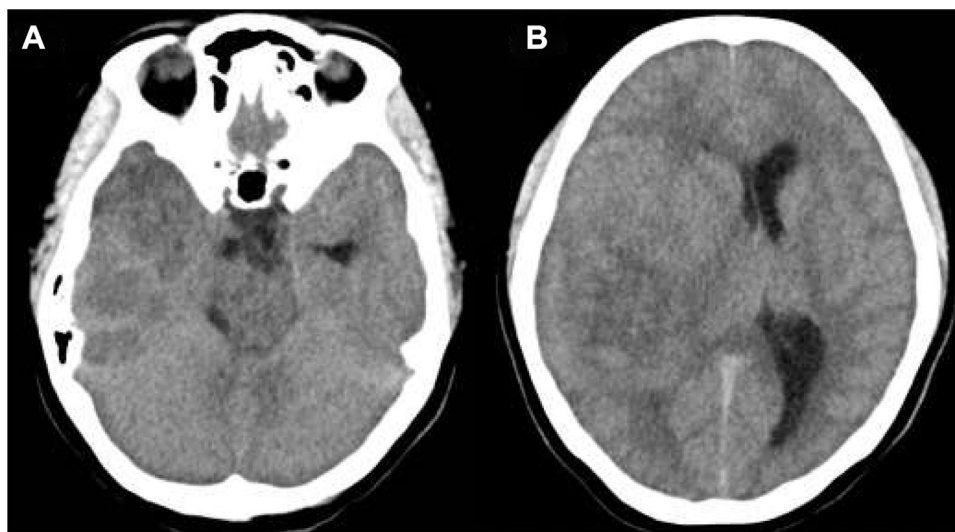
(A, B) Cranial plain CT shows a large occupying lesion with mixed density in the right temporal lobe, which is accompanied by a few high-density hemorrhages; the right ventricle is narrowed by compression, and the midline is shifted to the left.
